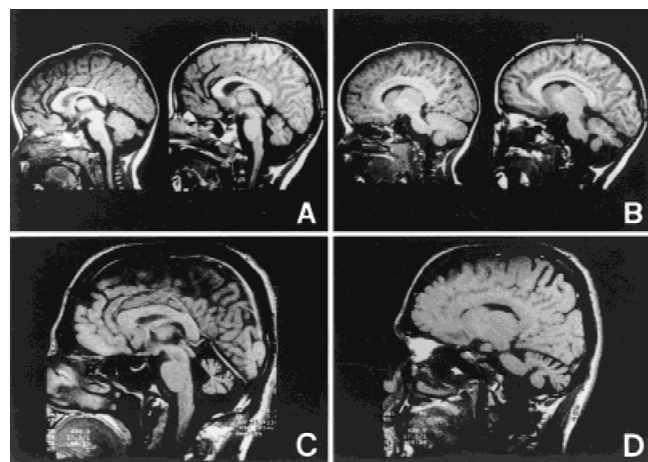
Brain MRI longitudinal T1 weighted sections of the propositus and his uncle. Median section (A) and paramedian section (B) on the left sides correspond to the propositus at age 2 years; the right sides of A and B correspond to age 3 years. Notice progressive atrophy of the cerebellum with age. Median section (C) and paramedian section (D) show marked atrophy of cerebellar folia in the maternal uncle.
